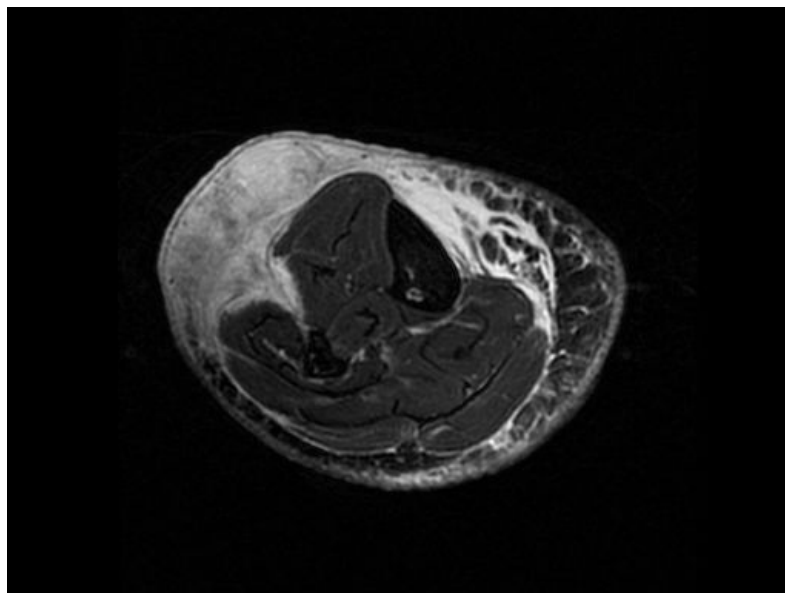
Magnetic Resonance Imaging showed an extra-aponeurotic mass affecting subcutaneous tissue with a T2 hypersignal.
